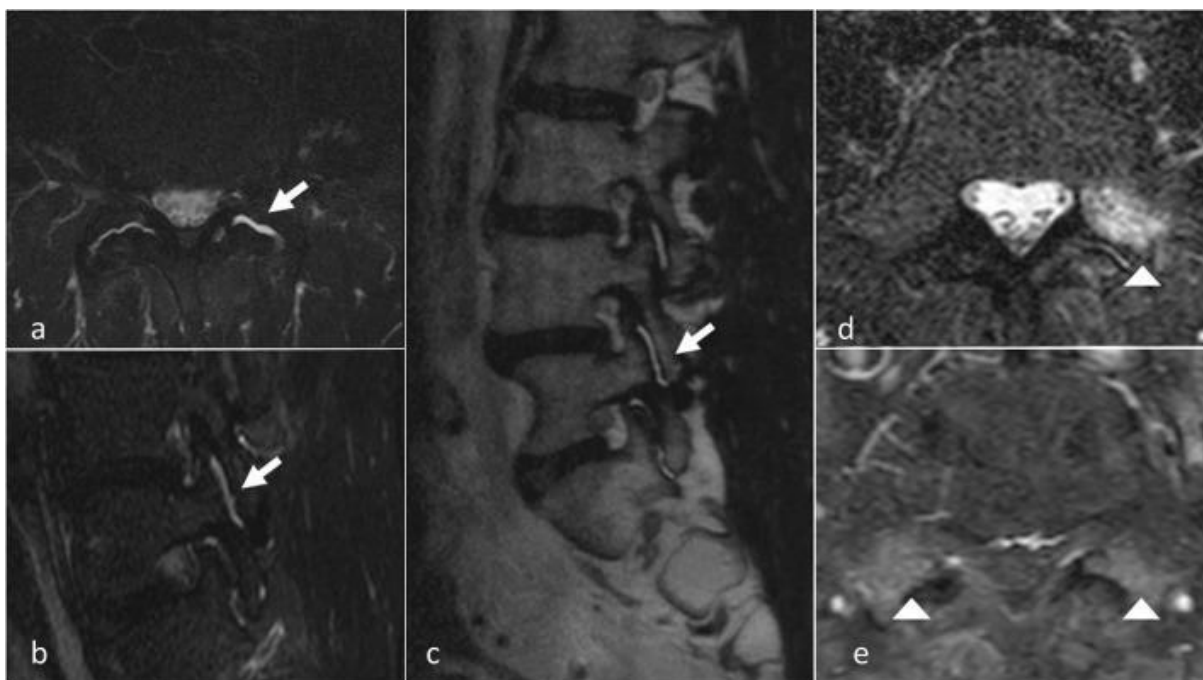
MRI of the FJs. There is inflammation in the synovial tissue and swelling within the joint.<sup>21</sup>
